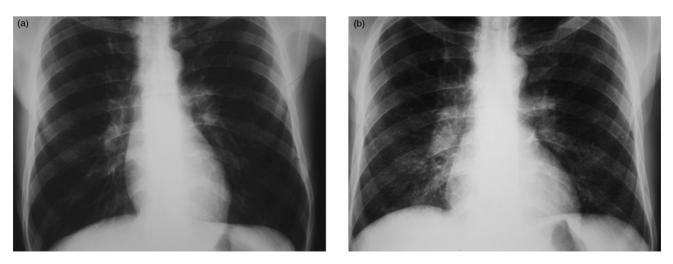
Chest radiograph at baseline (a) and after 13 days of antiretroviral therapy (b).
